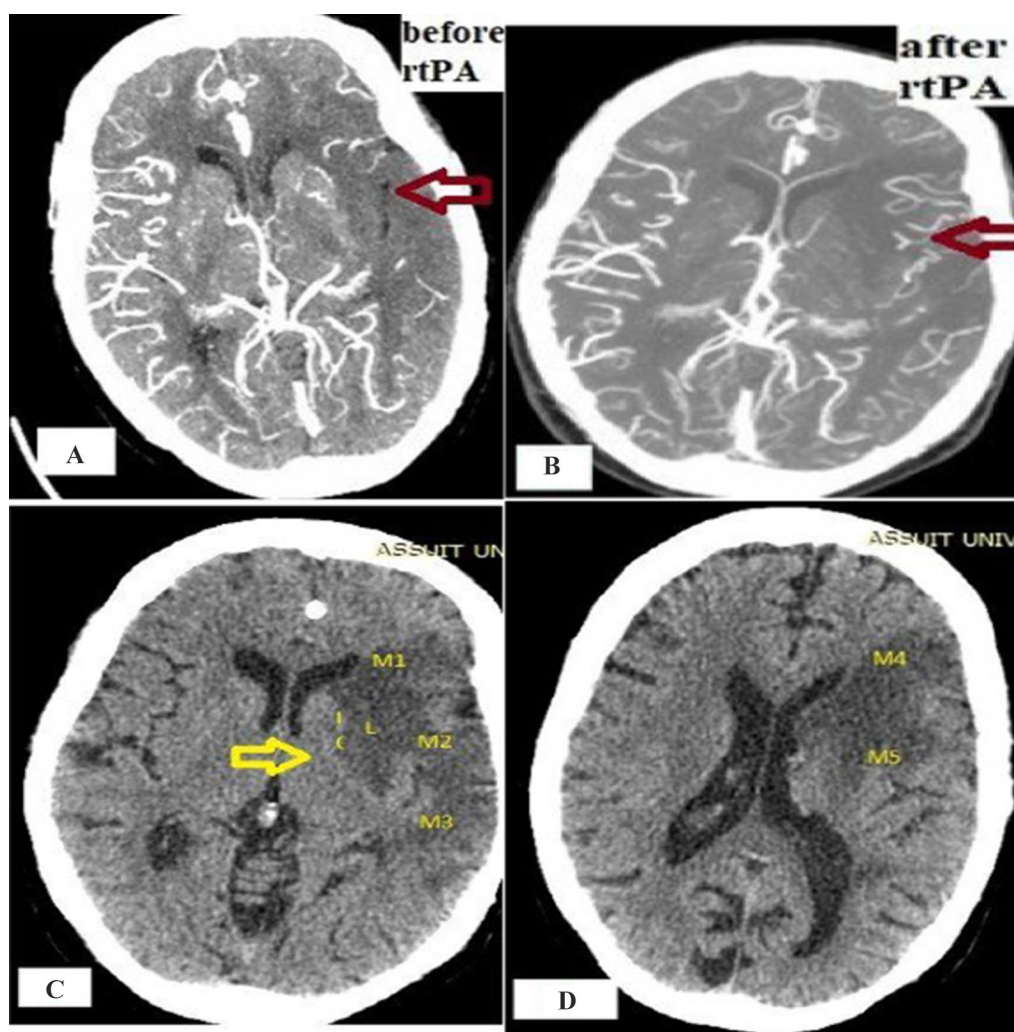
Patient with mRS 6. A Poor collateral status before rtPA injection. B Poor collateral status after rtPA injection. C, D, Worse ASPECT score = 2
